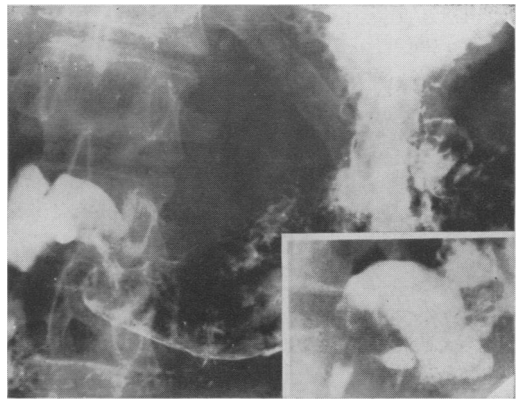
X-ray of C. R. W. taken October 20, 1953. The gastric ulcer has healed, but there is a new ulcer in the duodenal cap.
